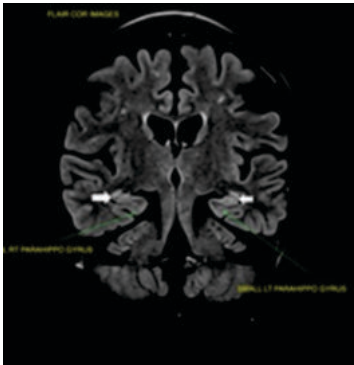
Bilateral small FLAIR hyperintense hippocampi (shown by short white arrows) in a middle aged adult male with few ischemic foci and history of unprovoked GTCS (bilateral mesial temporal sclerosis)
